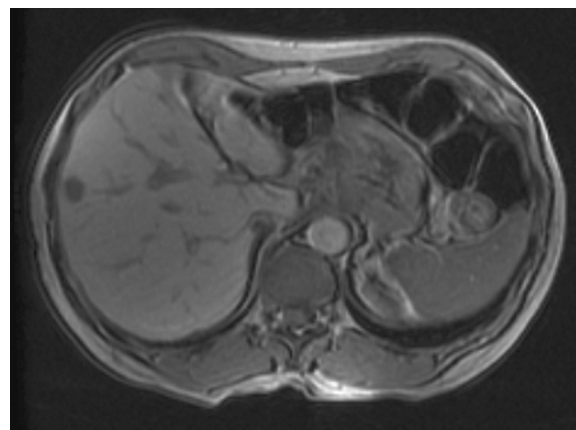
MR image demonstrating the lesion on segment 8 with characteristics of a metastasis and measuring 1.5 cm.
